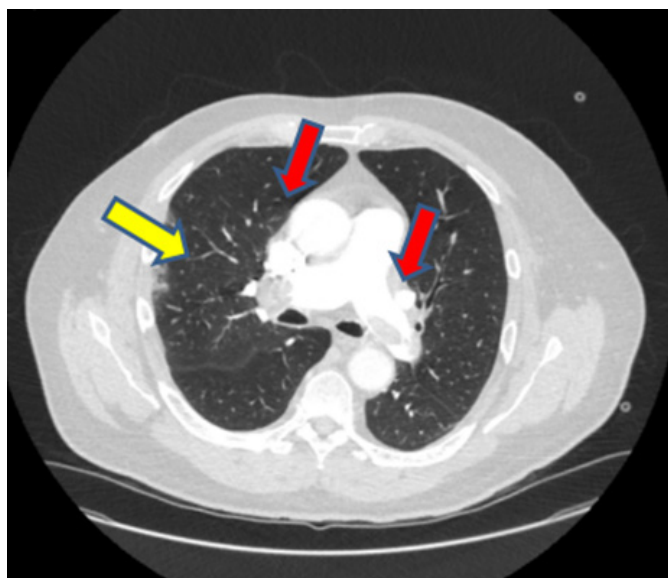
CT pulmonary angiogram red arrows indicate pulmonary emboli; yellow arrow shows ground-glass appearance.
